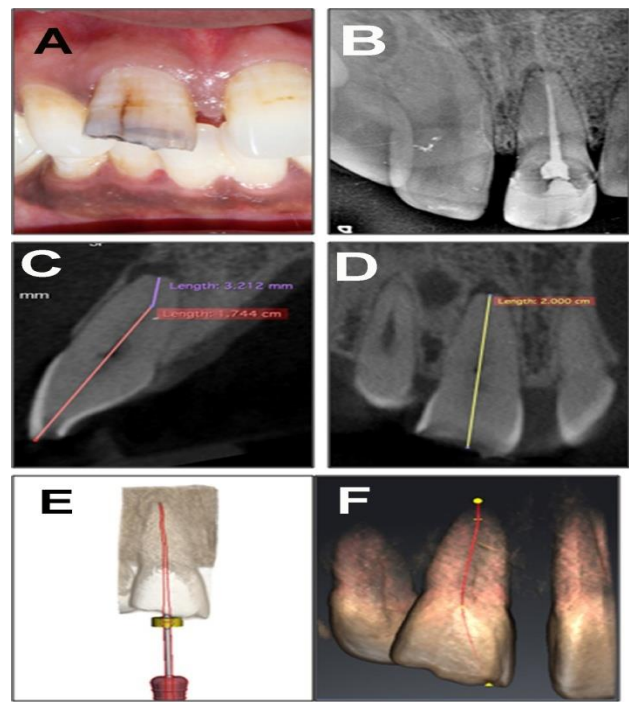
A. Preoperative photograph of the fractured right maxillary central incisor with PCO; B. Post obturation radiograph till the Root ZX working length measurement; C – F. CBCT preoperative measurements using Horos(C, D);3D Endo (E), and Sicat Endo software (F).
